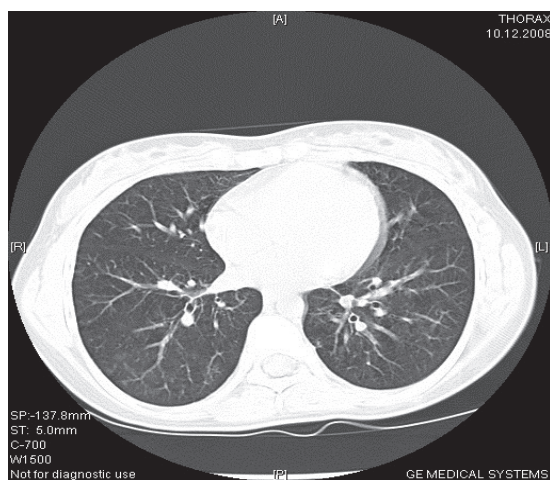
Control CT scan of patient #1. Nearly complete regression interstitial lung infiltration.
